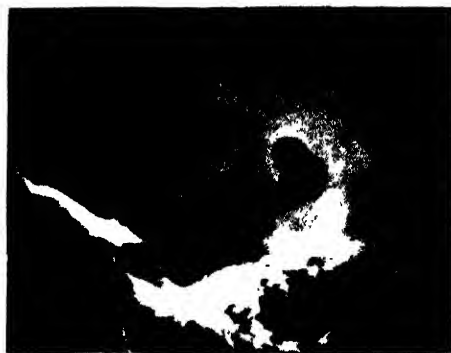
Lateral X-ray showing dermoid cyst of the diploe. The inner table has been penetrated by intracranial extension.
